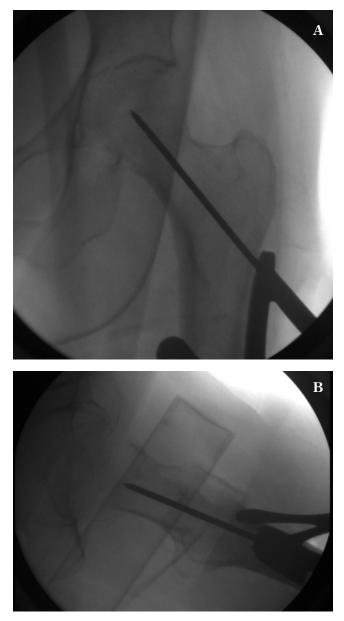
Use of a 130 degree angle guide to place a 3.0mm pin in the middle of the femoral neck and head on both the AP (a) and lateral (b) radiographs.
